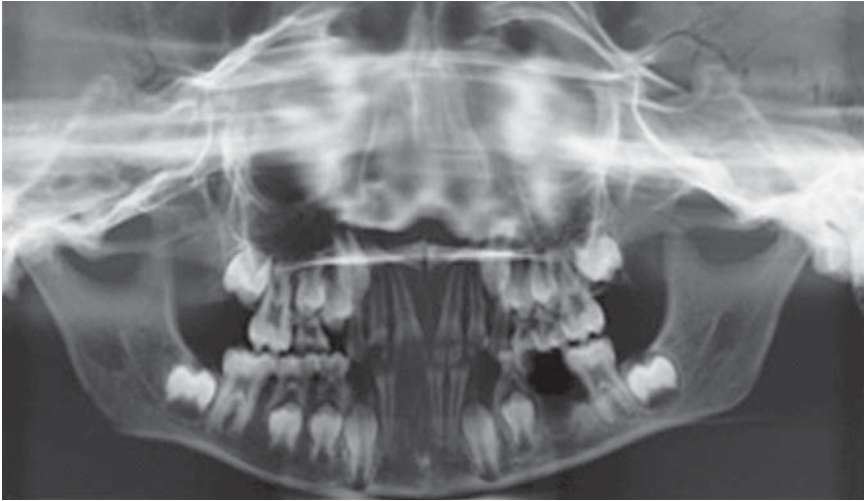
Orthopantomogram showing mixed dentition of a 6.5-year-old child. Courtesy of Alison Brough, East Midlands Forensic Pathology Unit, Leicester
